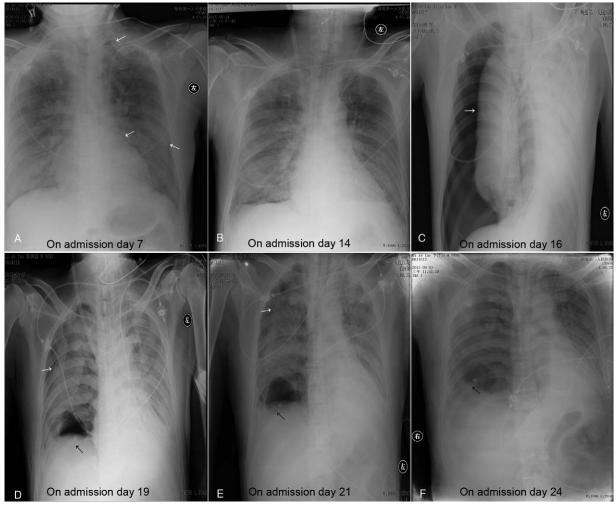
Chest x-rays showing the evolution of the lung changes after admission to ICU, with a reduction of bilateral interstitial infiltrates and a complete resolution of pneumothorax after ECMO and DFPP treatment (B–F). Chest x-ray before initiating the ECMO and DFPP (A). The white arrows indicate pneumothorax, the yellow arrow indicates pneumomediastinum, and the black arrows indicate pleural drainage. DFPP = double filtration plasmapheresis, ECMO = extracorporeal membrane oxygenation, ICU = intensive care unit.
